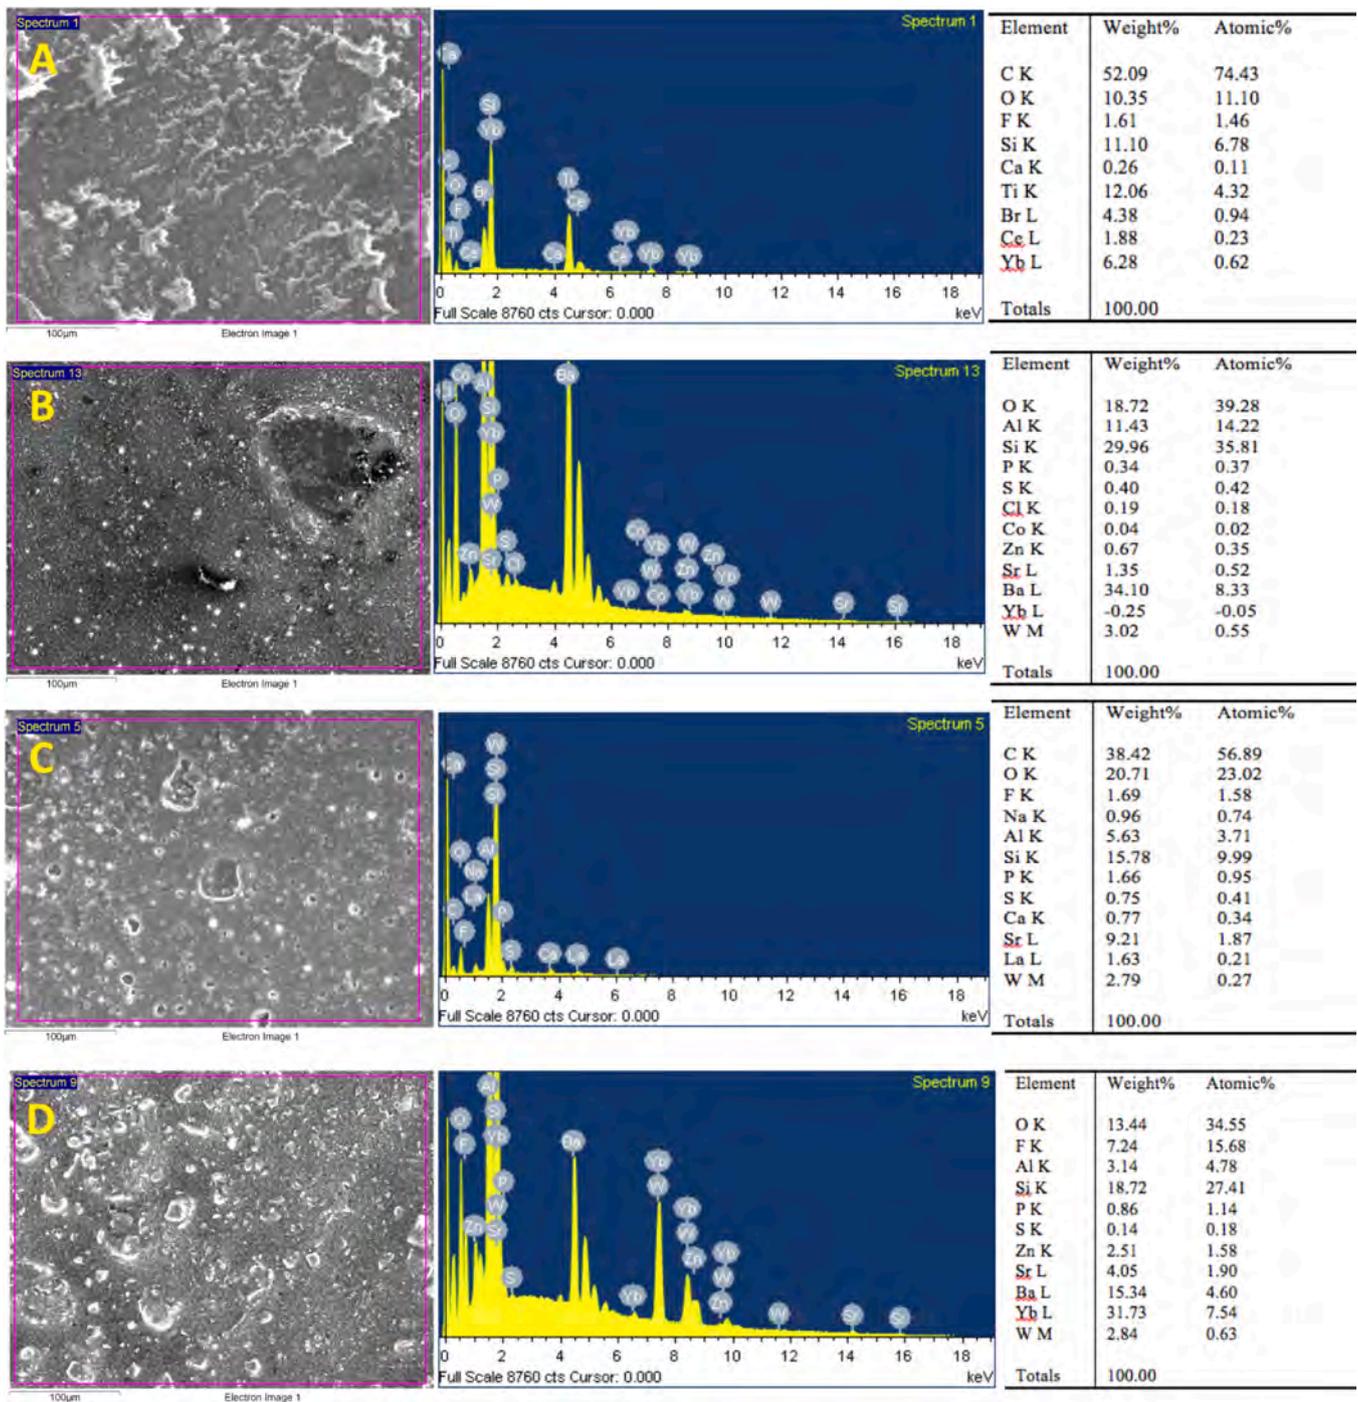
Morphological and chemical analysis by EDX. Surfaces of the different abutment cements were analyzed using SEM equipped with an energy-dispersive X-ray analysis. Results shown are representative from n=3 separate experiments using n=3 HGF samples isolated from different healthy donors.
